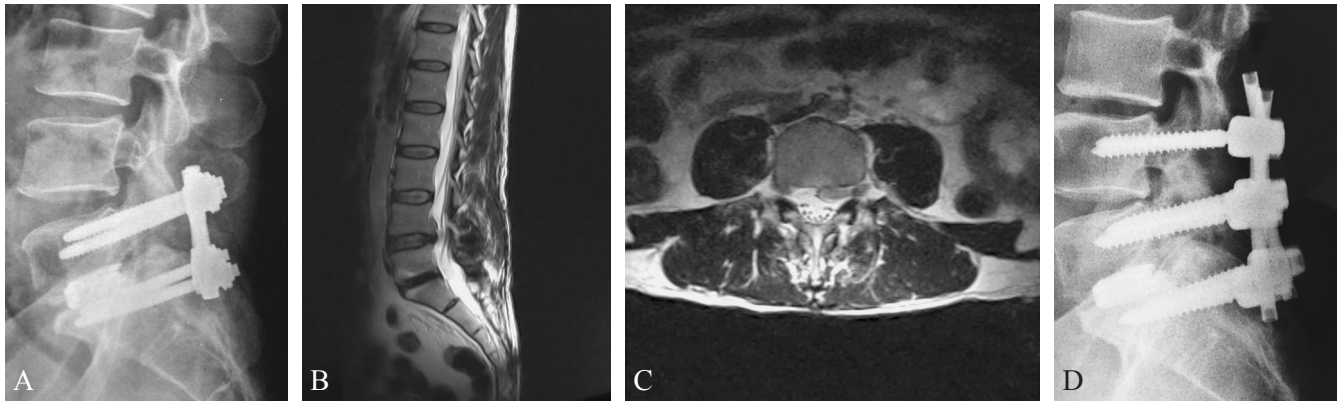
A 58-year-old man who previously underwent L5-S1 PLIF developed symptomatic herniated disc at L4-L5 9 years after the first surgery. Lateral radiography showing previous L5-S1 PLIF (A). Sagittal (B) and axial (C) T2-weighted magnetic resonance imaging demonstrating herniated disc at L4-L5. The patient underwent removal of the previous instrumentation and L4-S1 fusion with new synthesis material. Immediate postoperative lateral radiography showing L4-S1 fusion (D).
